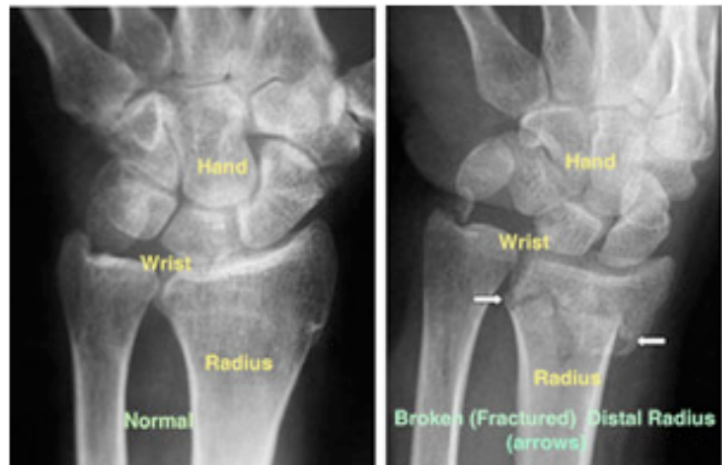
X-ray image of a normal wrist (left) and fractured wrist. [2]
